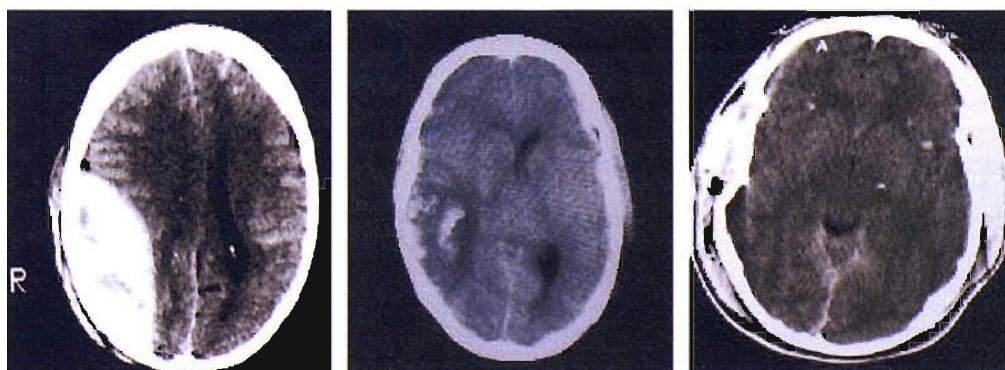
CT images demonstrating the variety of pathologies seen after TBI. From left to right; extradural haematoma, right parietal haemorrhagic contusion, multiple petechial haemorrhages, associated with diffuse axonal injury.
